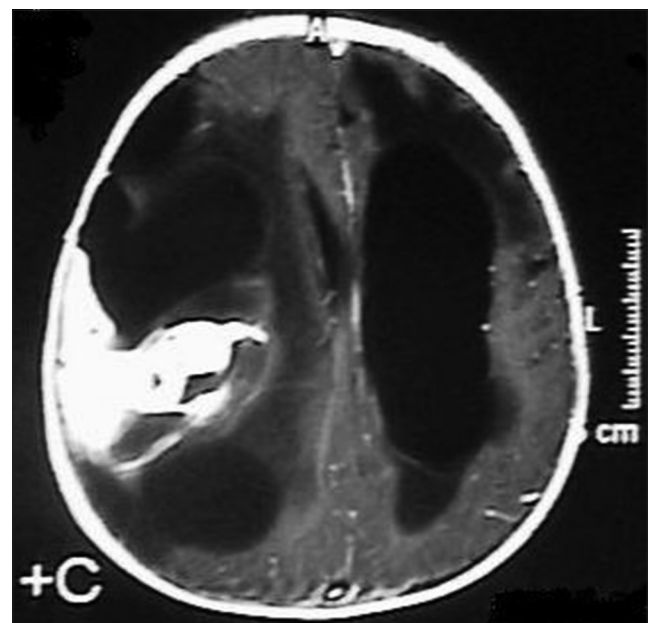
Axial T1-weighted MRI with gadolinium enhancement reveals a mass lesion with irregular borders with heterogeneous contrast enhancement extending posterior and superior towards the temporo-parietal structures accompanied by a non-enhancing cystic component
